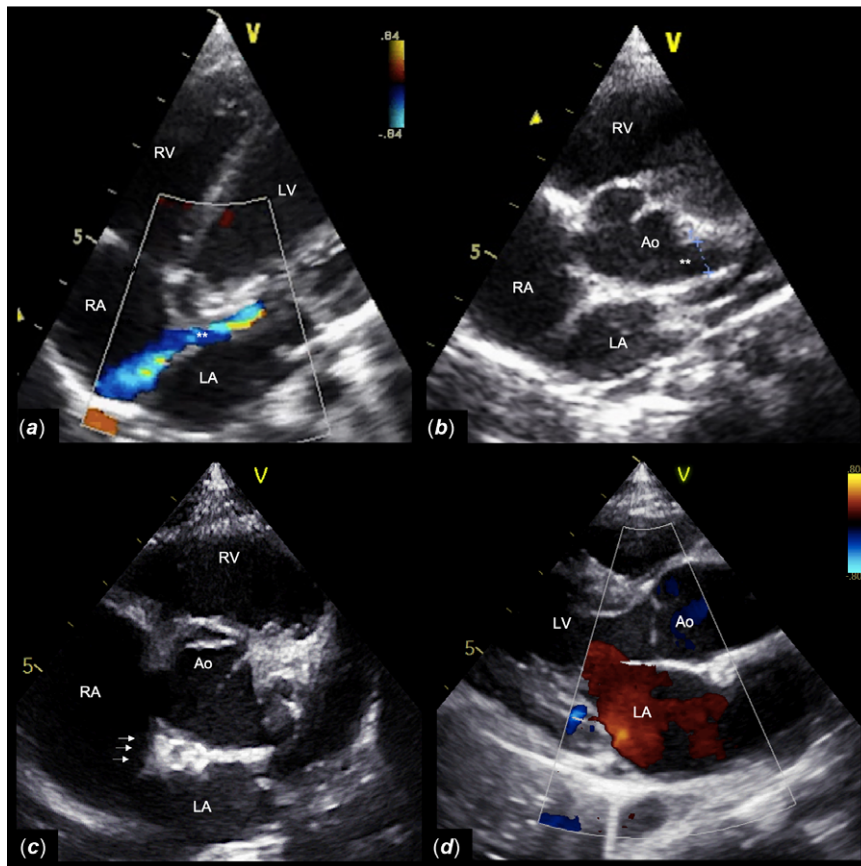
Echocardiogram with colour Doppler study before (a and b) and 12 months after (c and d) the transcatheter closure of the ruptured sinus of Valsalva aneurysm. A - 5-chamber view, shows an intracardiac shunt with a “wind-sock” appearance (). B - Short-axis view, shows an aneurysmatic left sinus of Valsalva (). C - Short-axis view shows a well-placed device (arrows). D - Long-axis view shows no aortic regurgitation. Ao = Aorta; LA = left atrium; RA = right atrium; RV = right ventricle.
